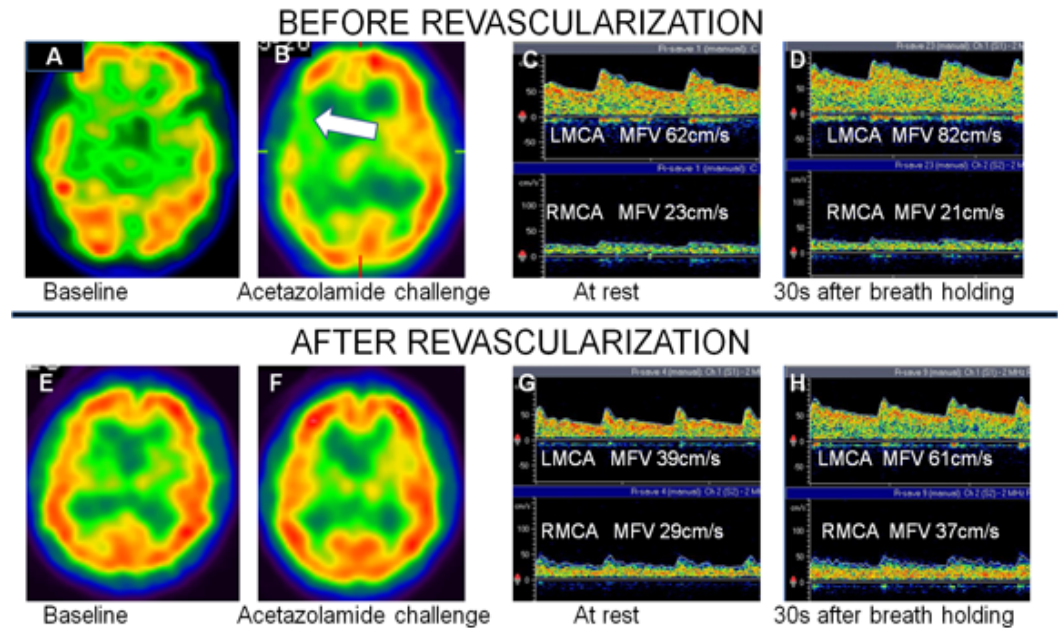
Hemodynamic consequences of a right internal carotid artery occlusive disease in Case 7. This 61 year-old man was having recurrent transient ischemic attacks referable to the right middle cerebral artery (MCA). Baseline HMPAO-SPECT (A) shows adequate perfusion in both cerebral hemispheres. SPECT images obtained after acetazolamide challenge (B) revealed markedly reduced perfusion in the right cerebral hemisphere, suggestive of a vasodilatory failure. Corresponding findings on transcranial Doppler vasomotor reactivity (VMR) by breath holding index (BHI) show a normal increase in mean flow velocity (MFV) in left MCA from 62cm/s at rest (C) to 82cm/s after 30 seconds of breath holding (D) with a BHI of 1.06. However, the paradoxical decrease in the MFV in right MCA from 23cm/s to 21cm/s during breath holding suggests an exhausted BHI.
